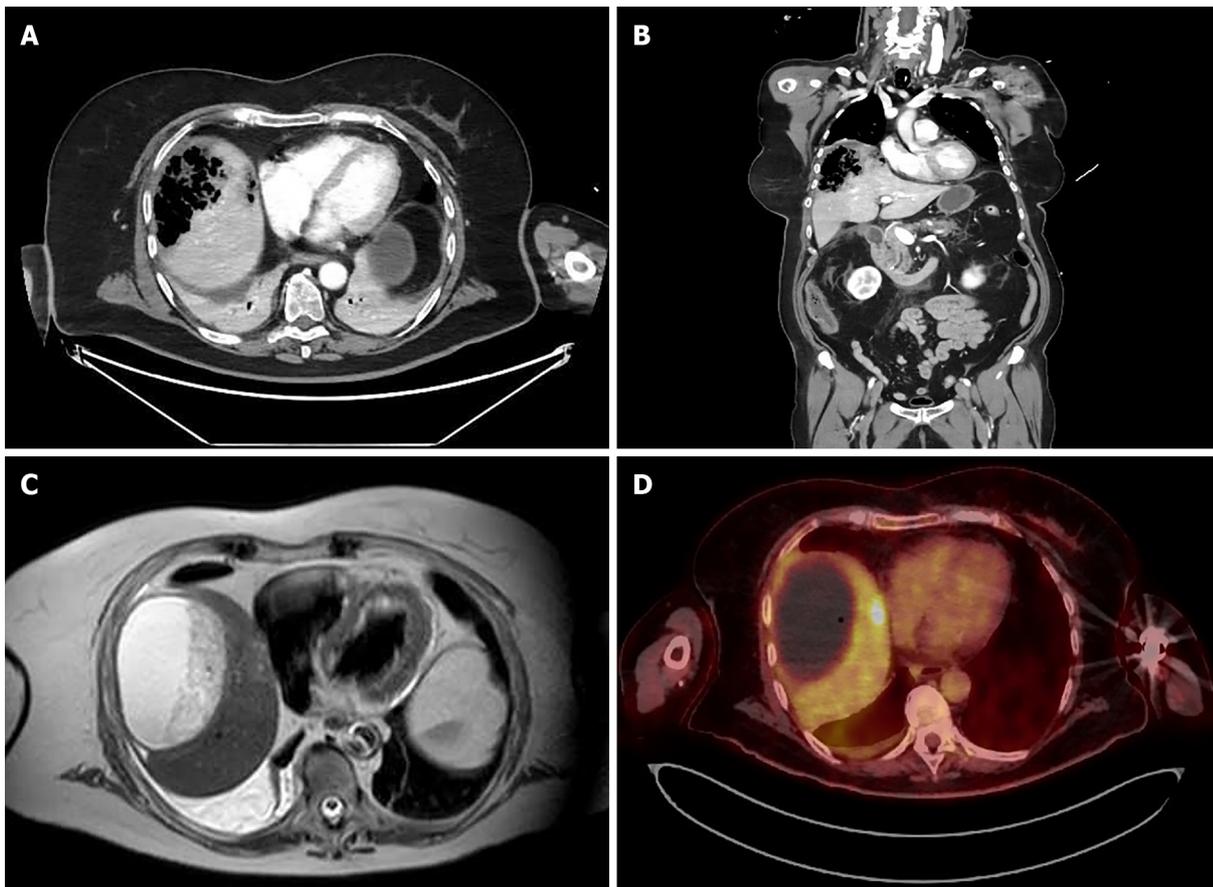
Imaging of emphysematous hepatitis. A and B: Axial (A) and coronal (B) computed tomography scans on admission, showing a 9 cm air-filled cavity in the right liver lobe; C: Magnetic resonance imaging, showing a 10 cm fluid-filled collection in the right liver lobe with heterogeneous content at 6 wk after initial presentation; D: Positron emission tomography performed at 9 wk after initial presentation, showing no metabolic activity in the large collection in the right liver lobe and a 2-cm nodule with positive metabolic activity in segment VIII.
